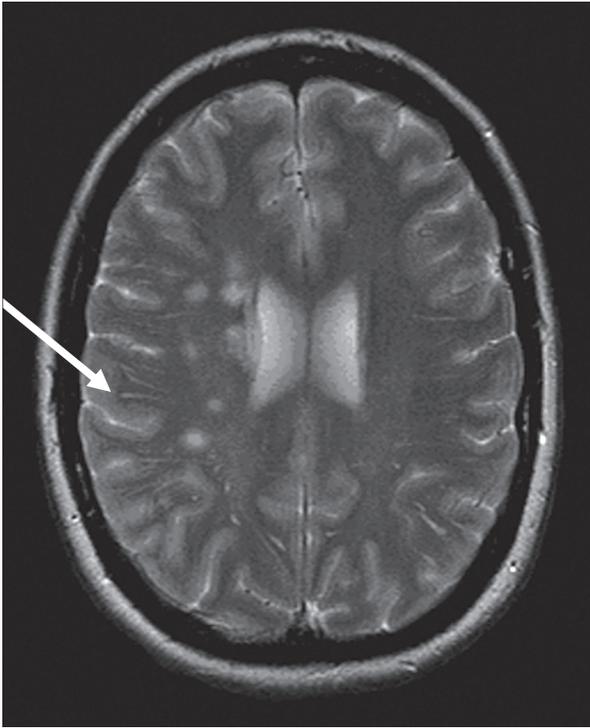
Right hemisphere borderzone infarcts seen on T2-weighted axial MR image. Image courtesy of Dr. Bernard Yan, Department of Neurology, Royal Melbourne Hospital.
